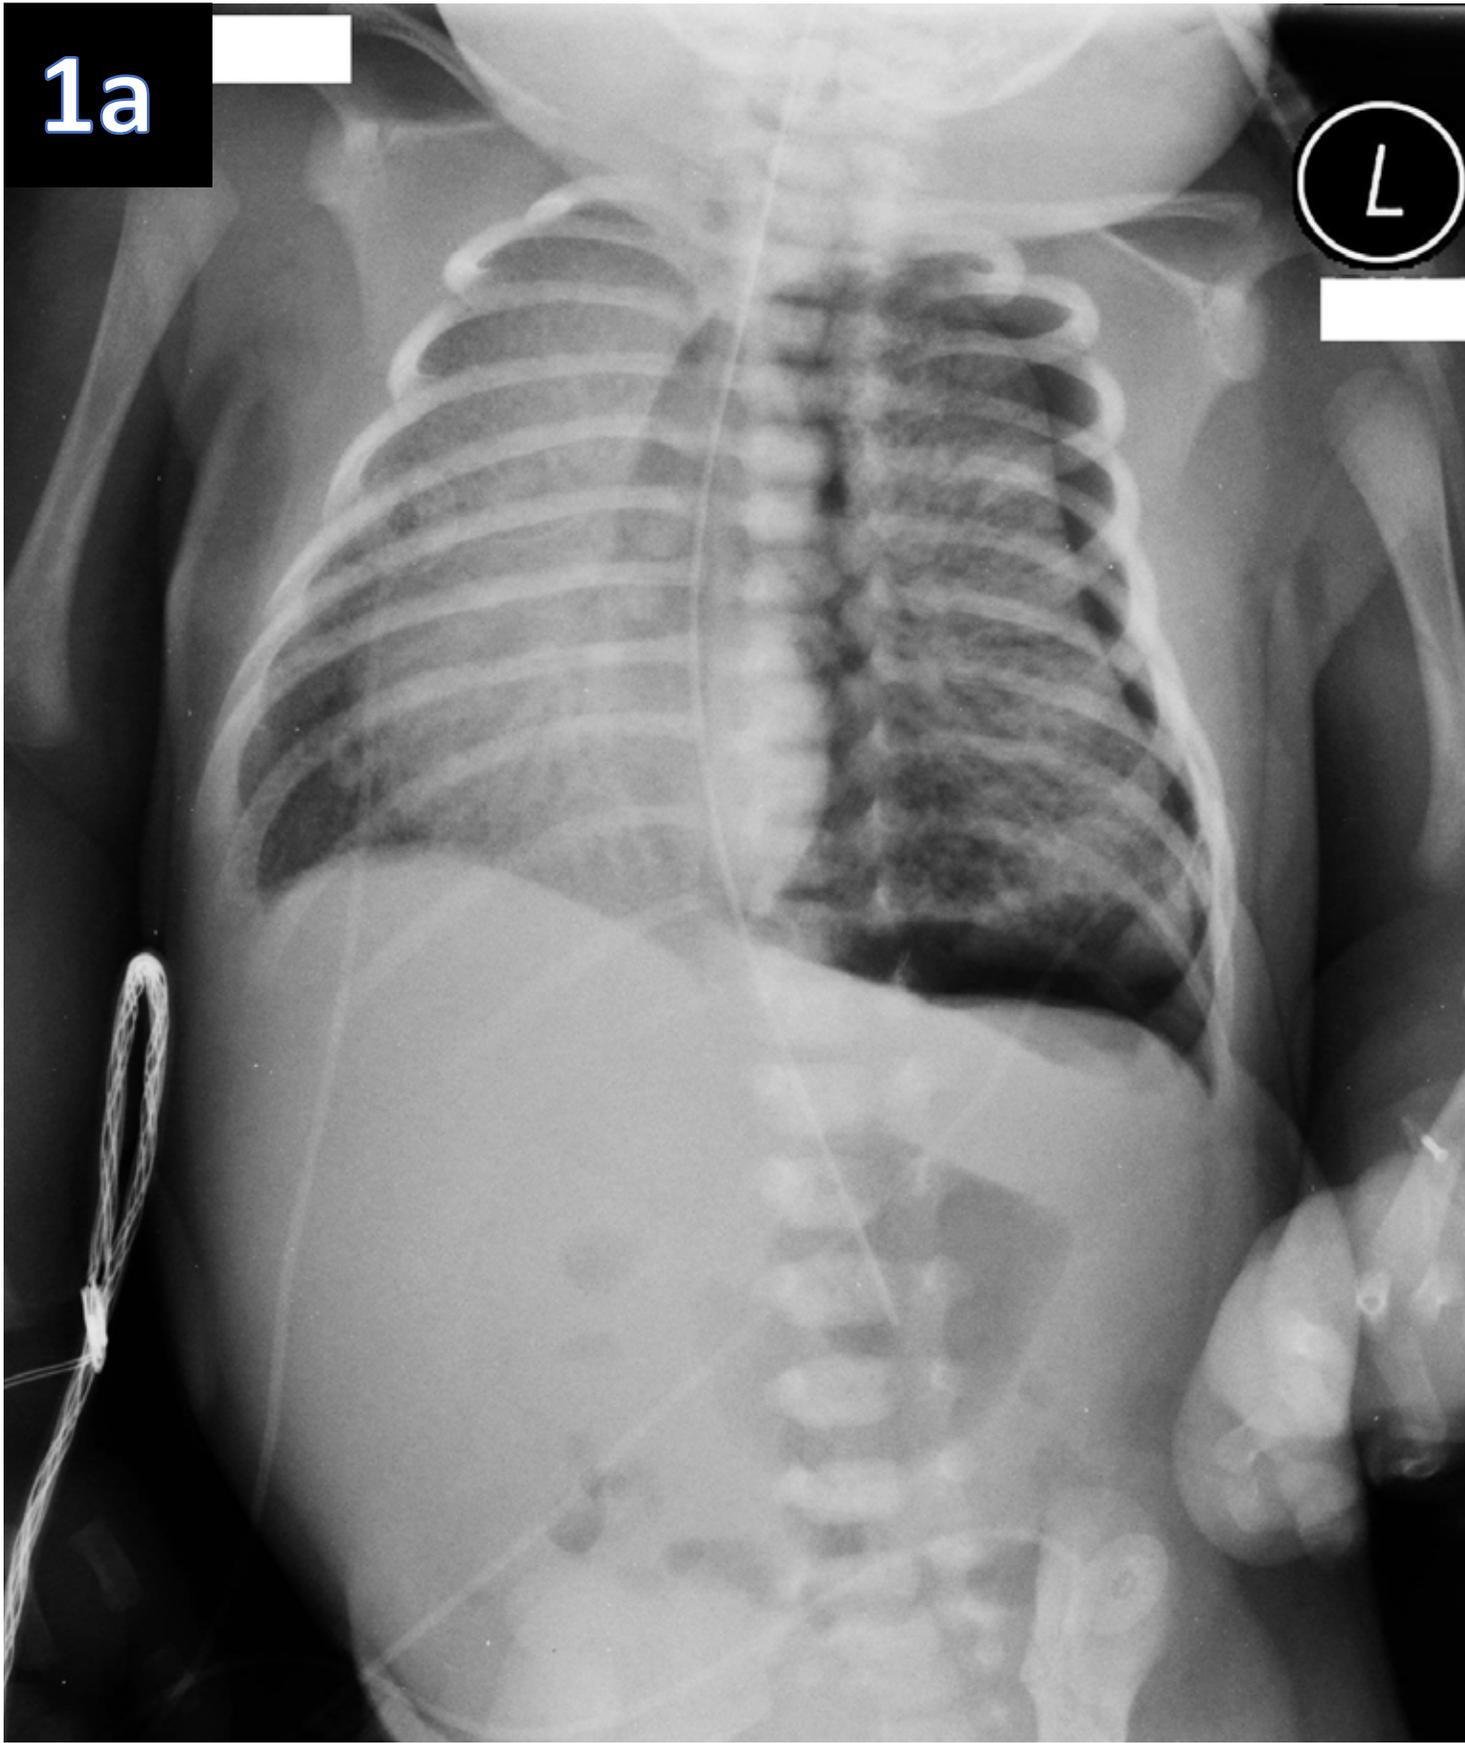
Chest x-ray showing large left sided pneumothorax and shifting of mediastinum to right side
